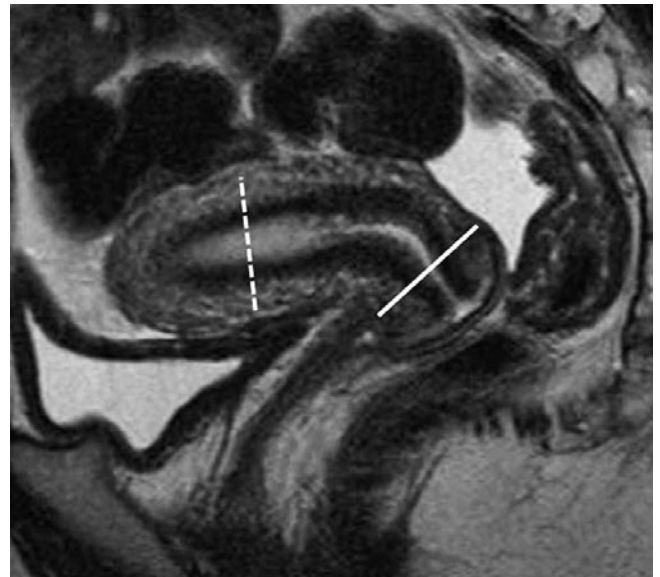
Sagittal T2-weighted image of the normal uterus showing zonal anatomy and planes used for small field-of-view imaging of cervical cancer (solid white line) and endometrial cancer (dashed white line)
